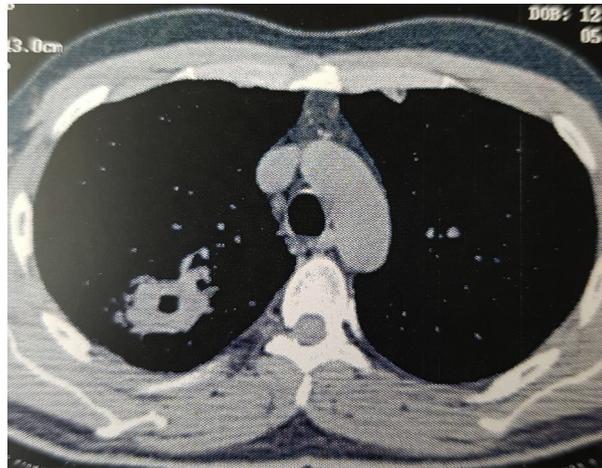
Chest CT scan image showing a consolidation with central escavation located in the posterior upper right pulmonary lobe, behind the right scapula. The consolidation, despite significant dimensions, does not show any contact to the pleura. Thus, it is not visible to transthoracic ultrasonography.
